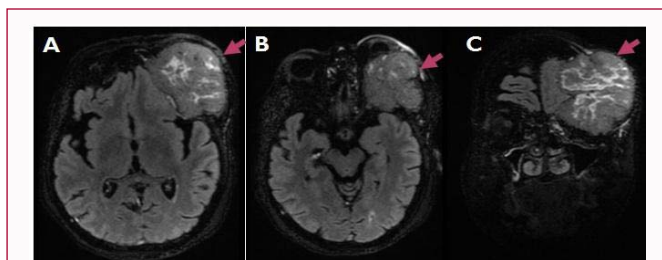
The MRI of the brain: A and B) Axial Flair C) Coronal Flair images showed destructive vascular extra cranial left frontal mass with intracranial and intra-orbital component invading the underlying frontal cortical sulci, the dura, the left lacrimal gland and possibly the left superior rectus muscle compressing the left optic nerve and the eye globe.
